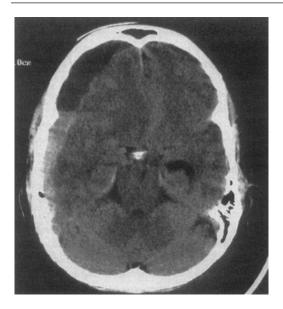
Uncal herniation on unenhanced axial CT due to subdural hematoma. The subdural bleed is seen on the right anterior aspect of the skull causing significant mass effect. From Eisenkraft B, Ortiz A. Imaging evaluation of cranial nerves 3, 4, and 6. Seminars In Ultrasound, CT, And MRI [serial online]. January 1, 2001;22:488–501. Reproduced with permission from Science Direct
